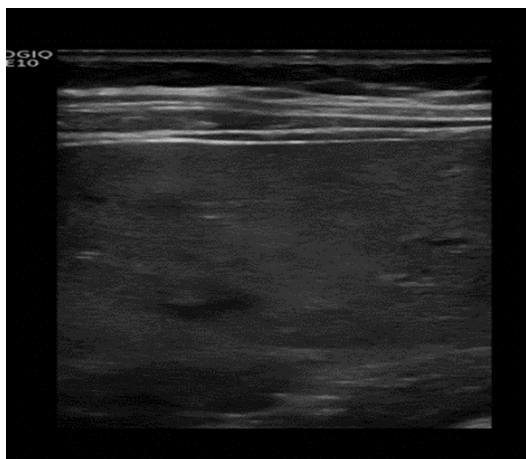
Liver Ultrasound showing Increased Echogenicity of the Liver.
